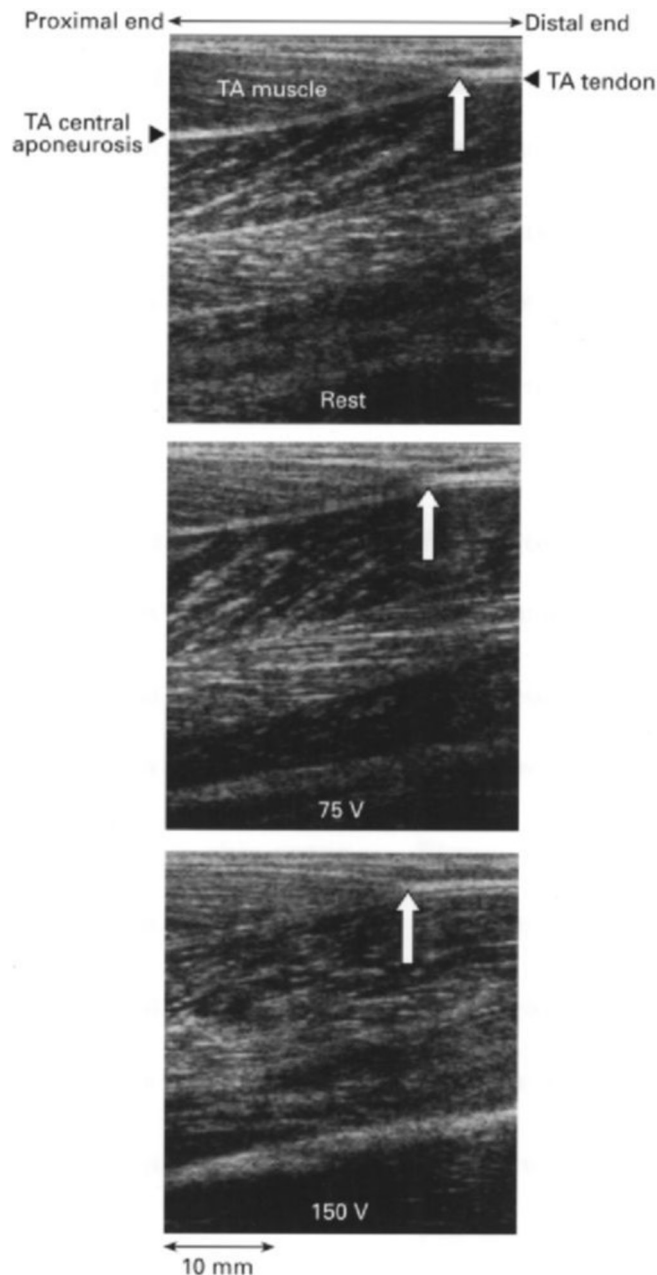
Tendon displacement measured by B-mode ultrasound. Sonographic images of the human tibialis anterior (TA) muscle at rest (top) and in response to electrical stimulation at 75 V (middle) and 150 V (bottom). The white arrow indicates the TA tendon origin. Notice the proximal shift of the TA tendon origin on electrical stimulation.⁸⁸
